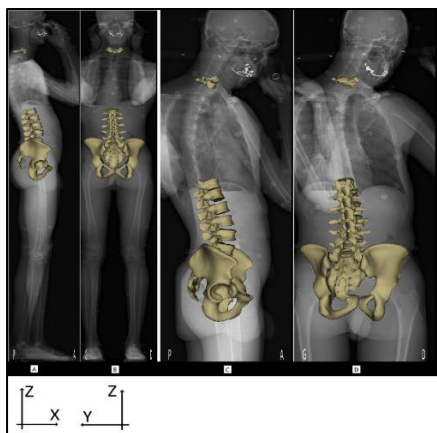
low dose biplanar radiographs. A-B : sagittal and frontal radiographs during the neutral position with superimposed 3D subject specific model, respectively. C-D : sagittal and frontal radiographs during the turned position of the trunk with superimposed 3D subject specific model, respectively. X : lateral bending, Y : flexion-extension, Z : axial rotation.
